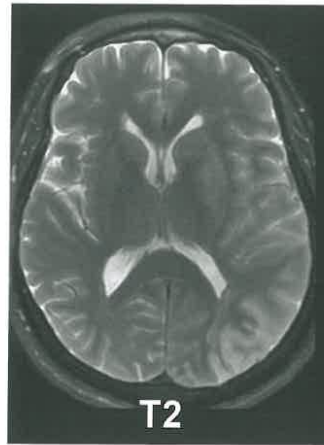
Edema in Stroke of Unknown Origin. Edema is detected as high signal intensity and there is a loss of flow voids in the left sylvian region. These findings are consistent with cytotoxic edema in acute ischemia. These findings show that if T2/FLAIR is negative, with only DWI being positive, the patient is not a candidate for IV TPA (based on the “tissue clock” concept).
